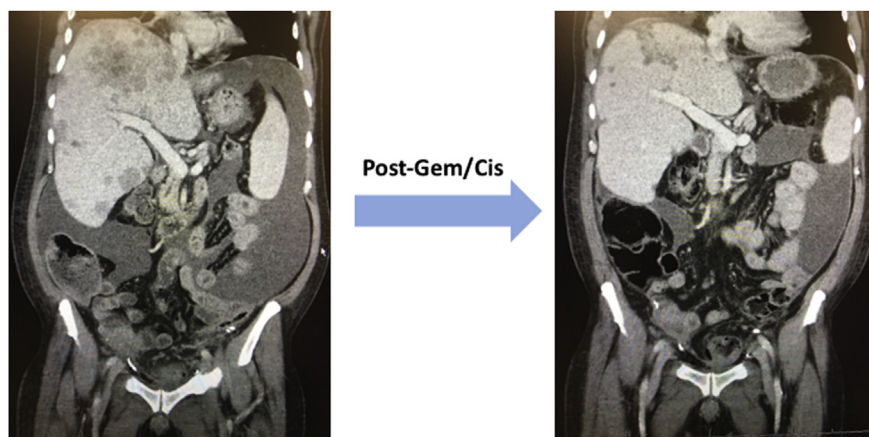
CT scan showing extensive hepatic metastases at 8 months post-cystectomy and bilateral native nephrectomy.
